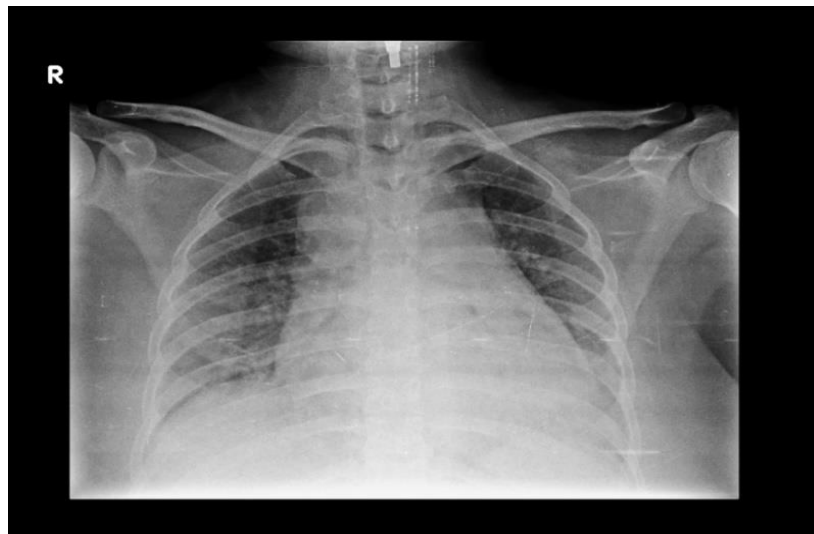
Bilateral lung infiltrates observed on chest X-ray
